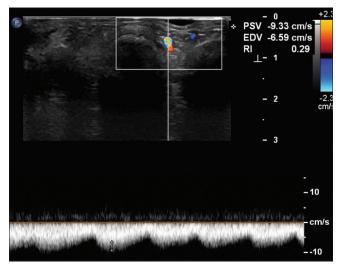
Axial pulse Doppler showing arterialization of the right middle finger digital vein due to shunting in the CM-AVM syndrome
